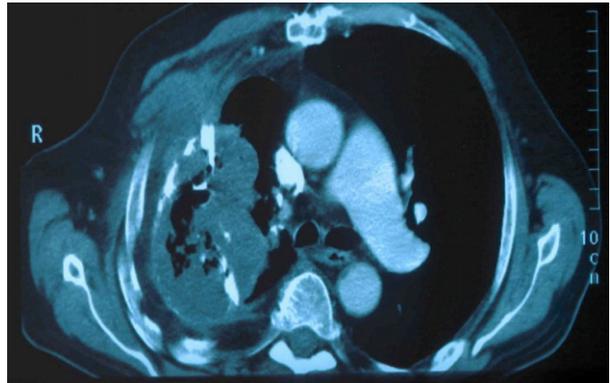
Chest x-ray showing a massive pyothorax surrounded by calcification and a round mass at the lower part of the pyothorax wall involving all layers of the chest wall anterolateral.
